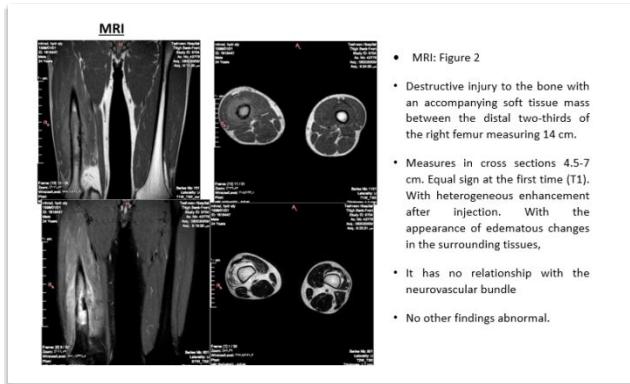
MRI of the femur
